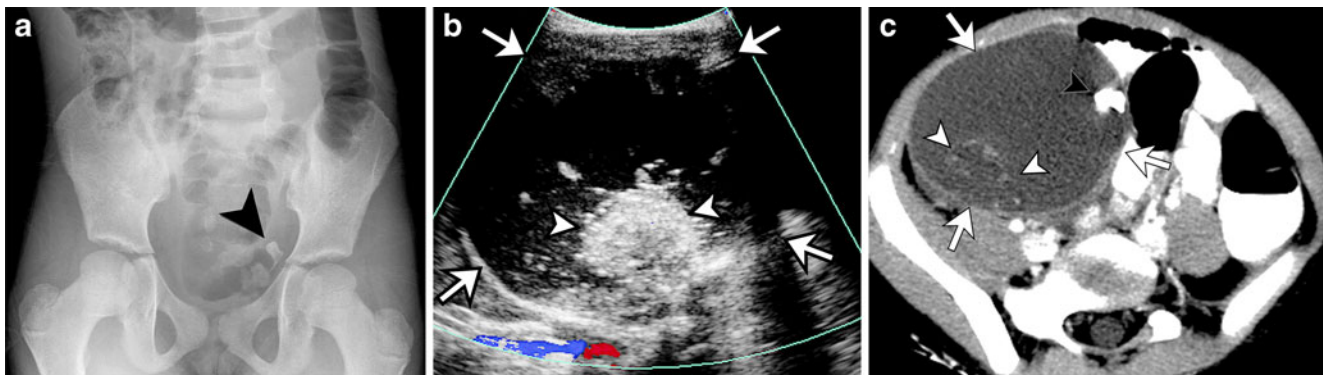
Mature ovarian teratoma and dermoid plug in a 7-year-old girl with abdominal pain for 2 days, emesis and anorexia. Imaging studies were requested to evaluate for appendicitis. a Abdominal radiograph reveals a tooth-like calcific density (*black arrowhead*) indicating concern for a teratoma. b Characteristic US appearance of a mature ovarian teratoma (*white arrows*), which appears as a cystic adnexal lesion with an echogenic nodule (*white arrowheads*), frequently
